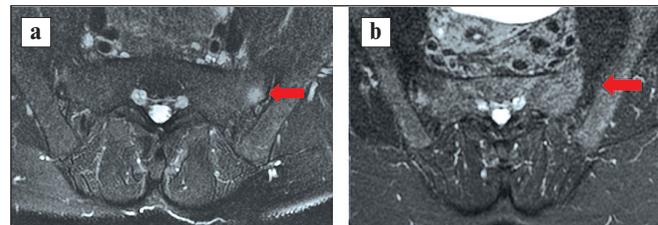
MRI of the SIJs using STIR before treatment (a) and after 24 weeks (b) of seniprutug therapy. Arrows indicate lesions: bone marrow edema – active left-sided sacroiliitis (a) and absence of pathologic changes (b)
